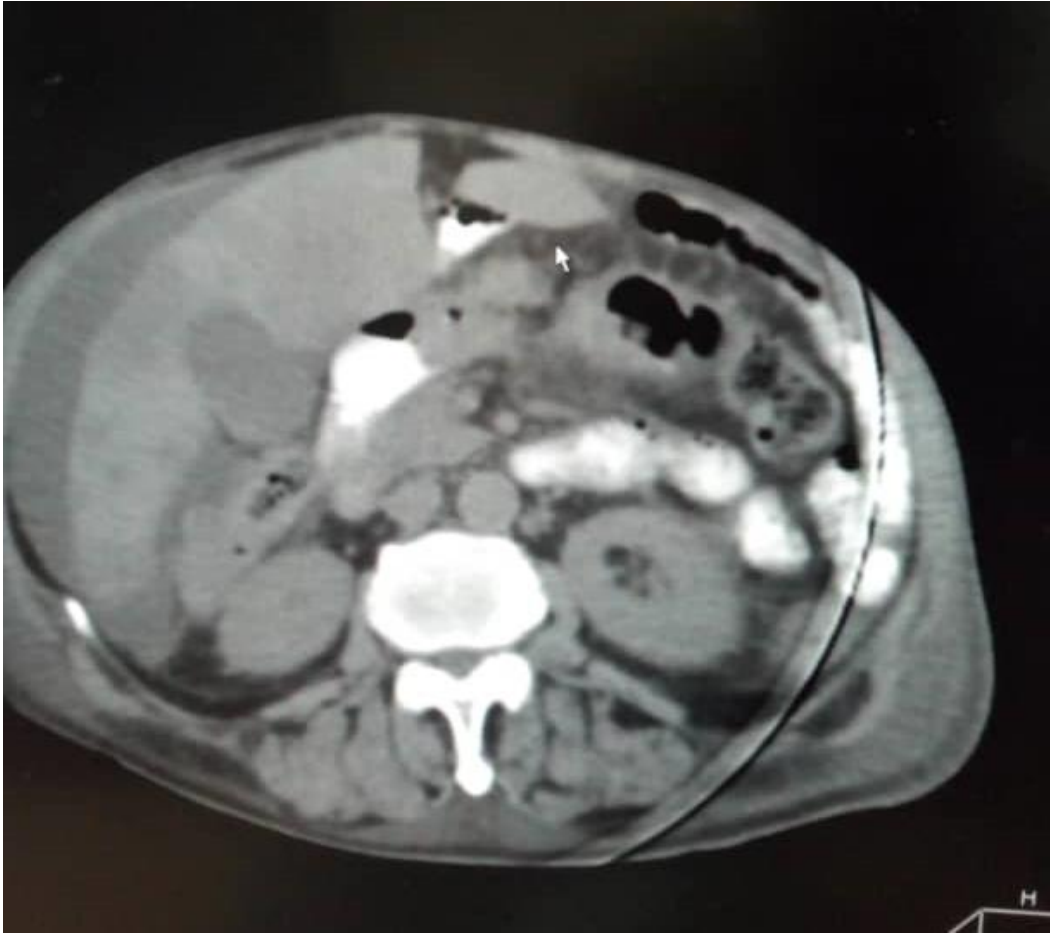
axial CT image of abdomen demonstrating mild ascites
